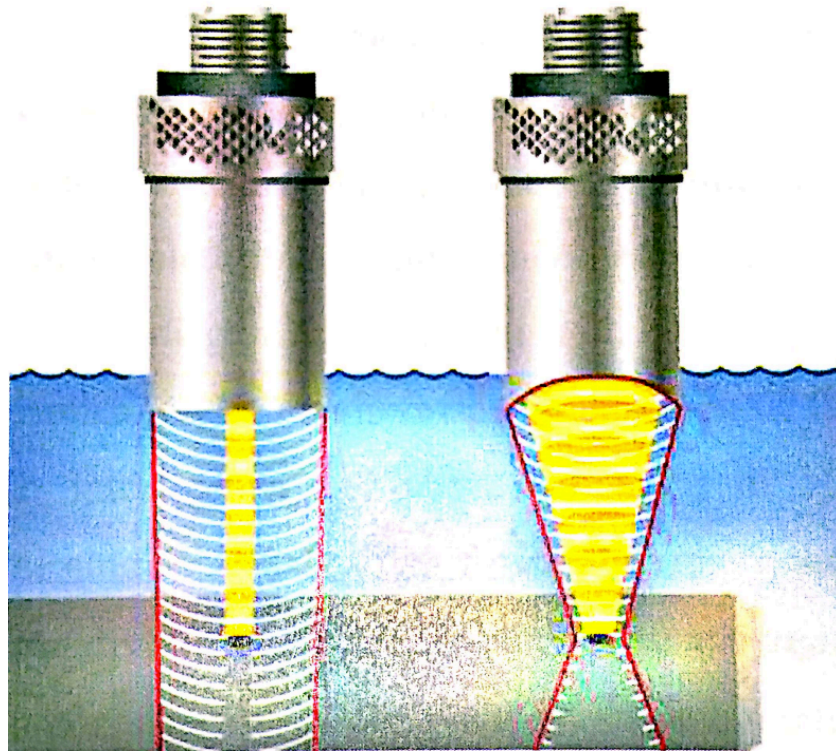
Focusing of the ultrasonic beam
